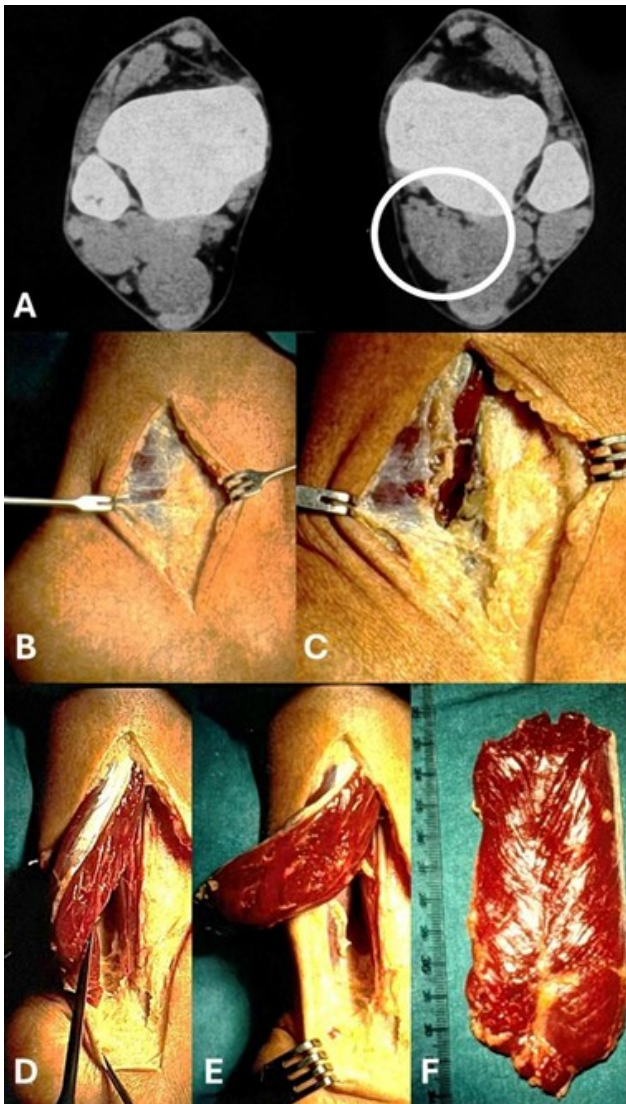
Case 1 with left accessory soleus muscle (ASM) and chronic posterior ankle pain. (A) CT with soft tissue windows (axial views) and visualization of the ASM (white circle). (B) Posteromedial approach and incision. (C) Blunt dissection. (D) ASM identification and isolation. (E) ASM excision. (F) Muscle belly after excision.
